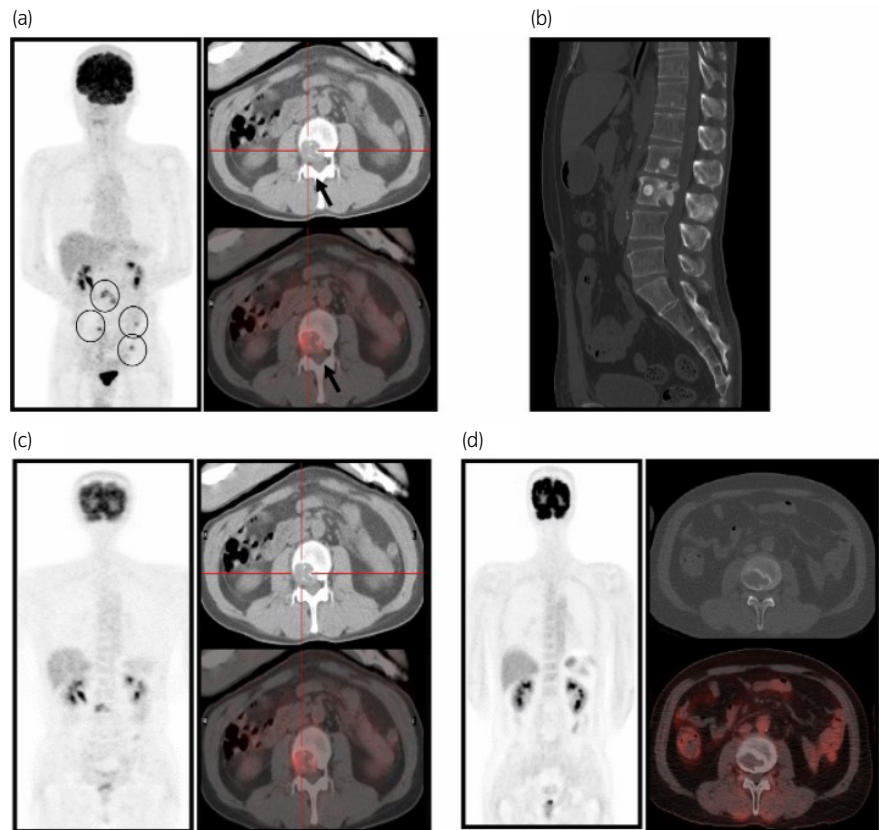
(a) FDG-PET/CT 1 month after RP. The black circles show abnormal uptake. (b) CT after two cycles of PI. The white arrow shows new osteolytic changes. FDG-PET/CT (c) before treatment with two cycles of PI and (d) after treatment with 15 cycles of AMR.
